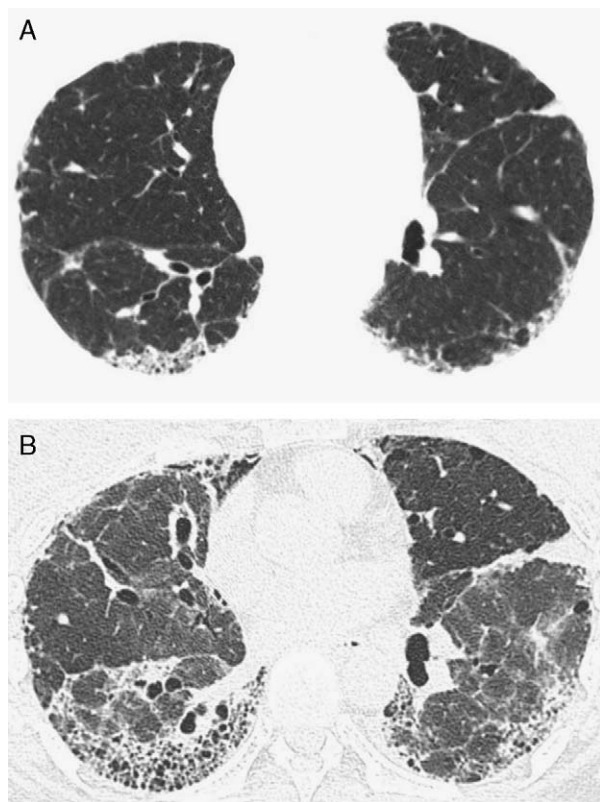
Acute exacerbation of idiopathic pulmonary fibrosis in a 53-year-old woman. A, HRCT image at the level of the lower lung zones shows mild peripheral reticulation and traction bronchiolectasis. B, HRCT image 1-year later when the patient presented with acute-onset shortness of breath and hypoxia shows progression of fibrosis with increase in the reticulation and development of honeycombing. Also noted are extensive bilateral ground-glass opacities and pneumomediastinum. Surgical biopsy showed diffuse alveolar damage superimposed on a background of usual interstitial pneumonia.
